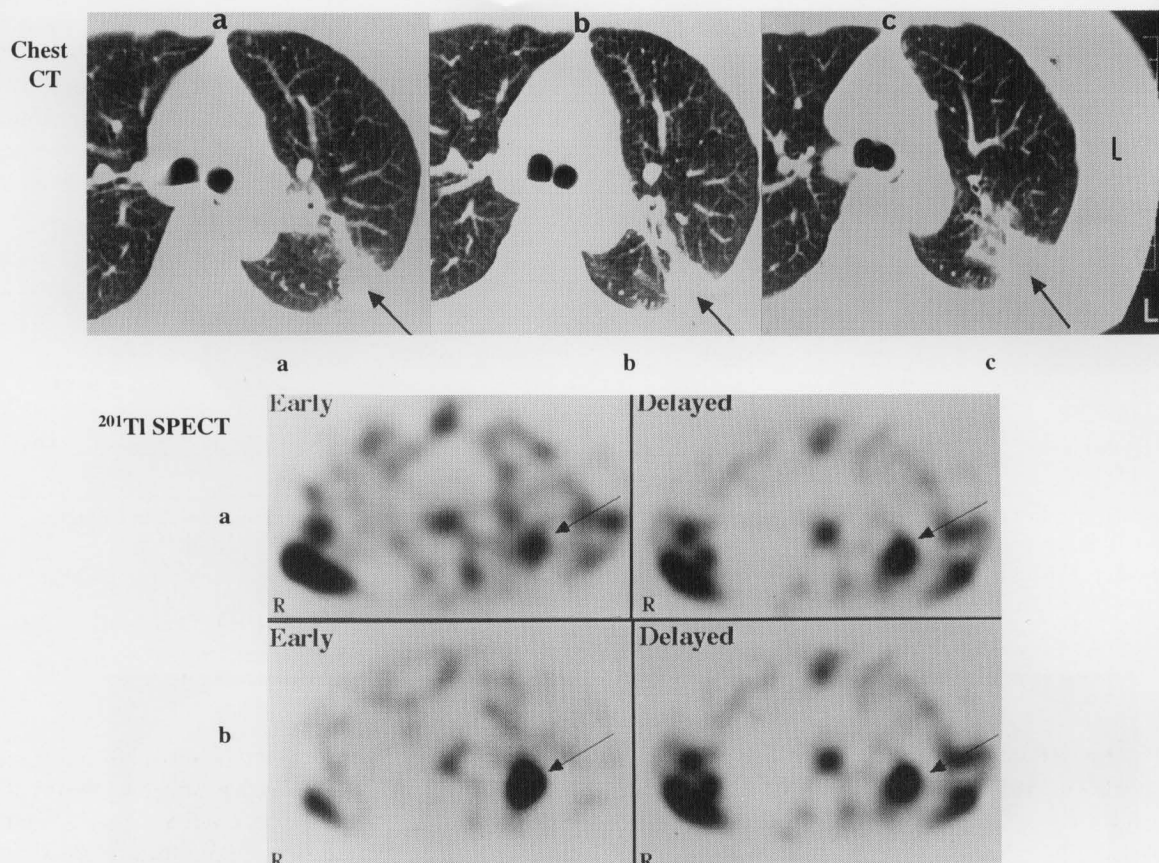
Chest CT and ^{201}Tl SPECT scans in a case of progressive disease (PD), a 56-yr-old male with adenocarcinoma (# 20 in Table 1). Chest CT scan showing a tumor measuring 22×24 mm in the left dorsal lung before therapy (a; arrow). At the accumulated tumor dose of 28 Gy combined with one course of chemotherapy (cisplatin), the tumor size had not changed noticeably (b; arrow); the tumor subsequently increased to 34×43 mm 21 weeks after the end of radiationtherapy with a total dose of 54 Gy and 2 additional courses of chemotherapy (c; arrow). On ^{201}Tl SPECT, there was only slight reduction of delayed uptake ratio (DUR) and retention index (RI) in the tumors (arrows) after a 28 Gy-dose irradiation (b) compared to the pretreatment values (a) (DUR; from 4.0 to 3.7, RI; from 24.7% to 22.5%).
